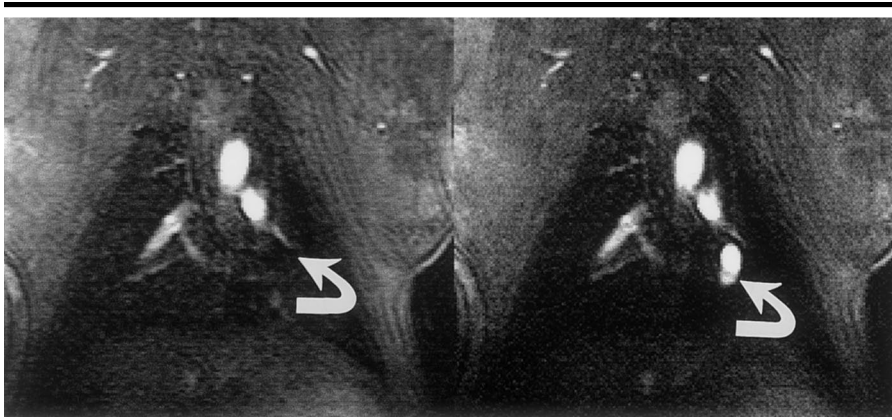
Oblique coronal T1-weighted turbo field-echo MR images (3.9/1.3) of lung. Tip of balloon catheter was filled with either (left) air (arrow) or (right) 1% solution of gadodiamide (arrow). Visualization of air-filled balloon against low-signal-intensity background of lung was not possible. In contrast, gadodiamide-doped balloon was reliably visualized and helped confirm position of catheter tip in distal branch of pulmonary arteries.
